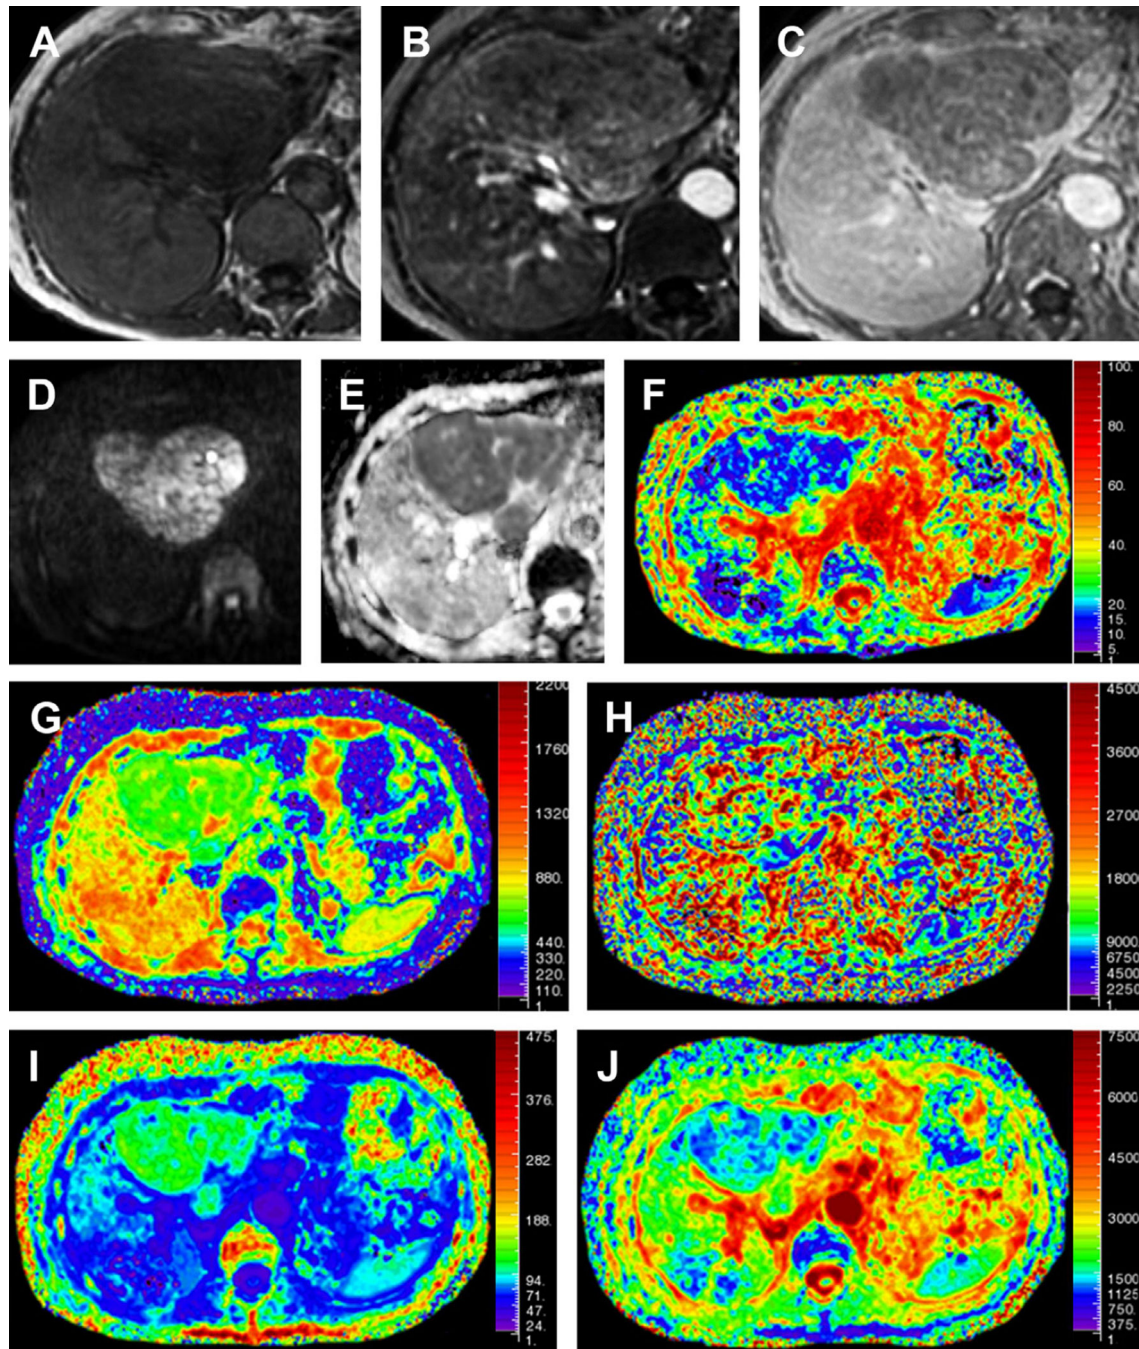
DWI of HCC analyzed with different models of signal decay. (A–C) Precontrast, arterial, and venous phases of DCE-MR imaging show a large focal liver lesion with heterogeneous wash-in during arterial phase and posterior washout. (D) DWI with b value of 2000 s/mm^2 shows high SI of the lesion and (E) very low ADC value ($0.65 \times 10^{-3} \text{ mm}^2/\text{s}$). IVIM model confirms the restriction of water diffusion of the lesion in the (F) D map with a value of $0.6 \times 10^{-3} \text{ mm}^2/\text{s}$. (G) Increased perfusion fraction (16%) and (H) pseudodiffusion value (D^* :
